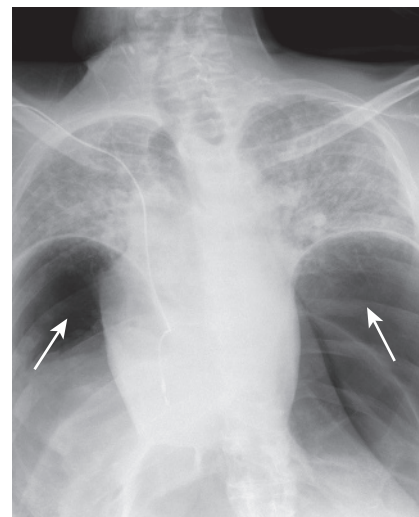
Chest radiograph demonstrating a large volume of free intraperitoneal gas (*arrows*), with marked diaphragmatic elevation indicating a rare tension pneumoperitoneum.
